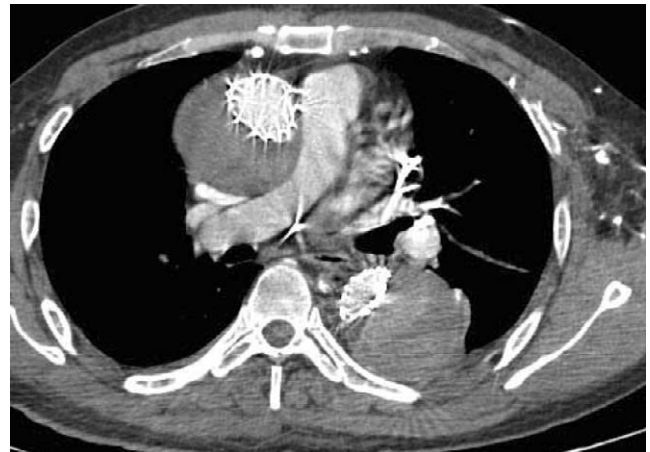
Follow-up computed tomography shows complete seal with thrombosis in the ascending and descending thoracic aortic false lumen.
